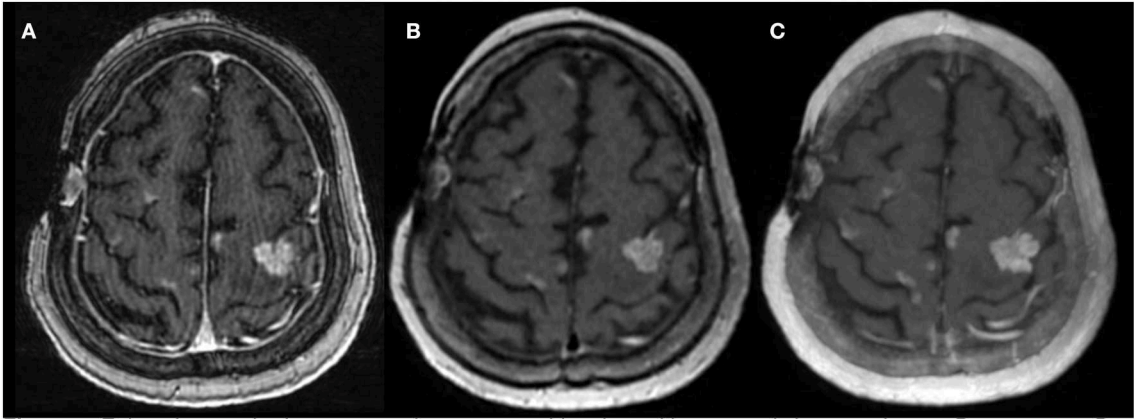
Enhancing cerebral metastases in a 78-years-old patient with metastatic lung carcinoma. Postcontrast 3D T1-weighted (A) FSPGR, (B) CUBE, and (C) overlapping CUBE maximum intensity projection (oC-MIP) images demonstrate enhancing metastatic lesions. The lesions appear most conspicuous with overlapping CUBE MIPs (C). The contrast-to-noise ratio of lesions is also highest for oC-MIP (C).
